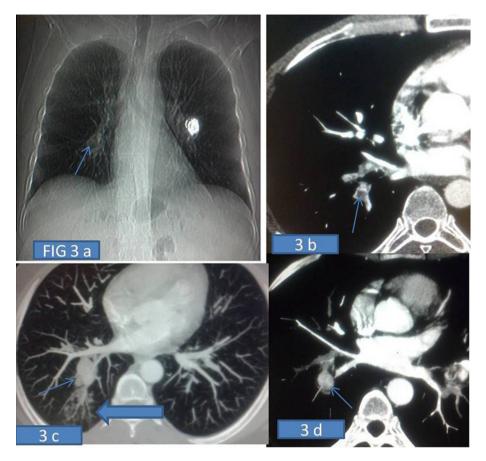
a. CT scanogram showing right infrahilar opacity (arrow) suggesting some vascular pathology. b. CT angiogram image at the time of first episode showed no aneurysm in the right pulmonary artery branch (arrow). c. CT Angiogram Lung window image showing right descending pulmonary artery branch aneurysm (arrow) with surrounding parenchyma showing groundglass and alveolar haemorrhage (thick arrow). 3d. CT Angiogram showing right descending pulmonary artery aneurysm (arrow) which was not there in earlier CT as shown in Fig. 3b by arrow.
